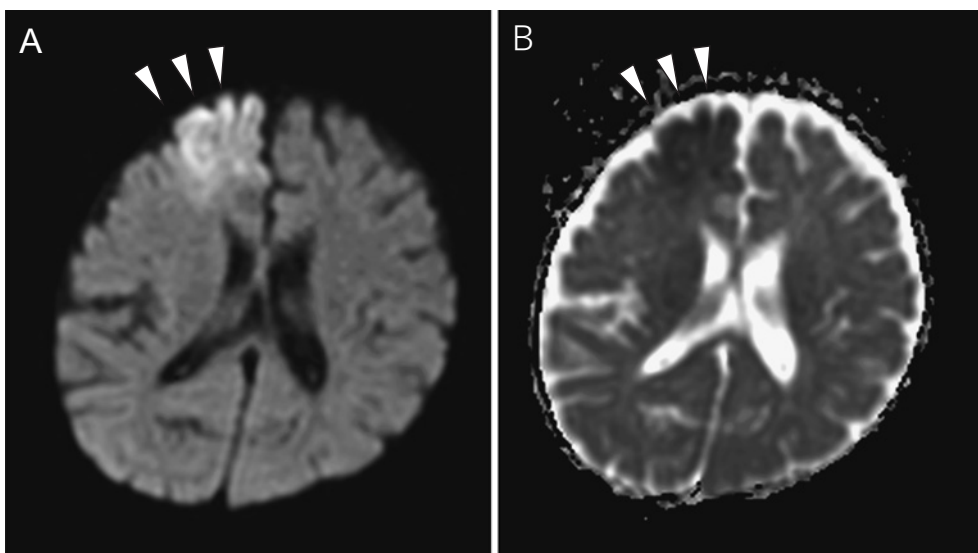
Brain MRI images suggesting cerebral infarction in the right frontal lobe.
